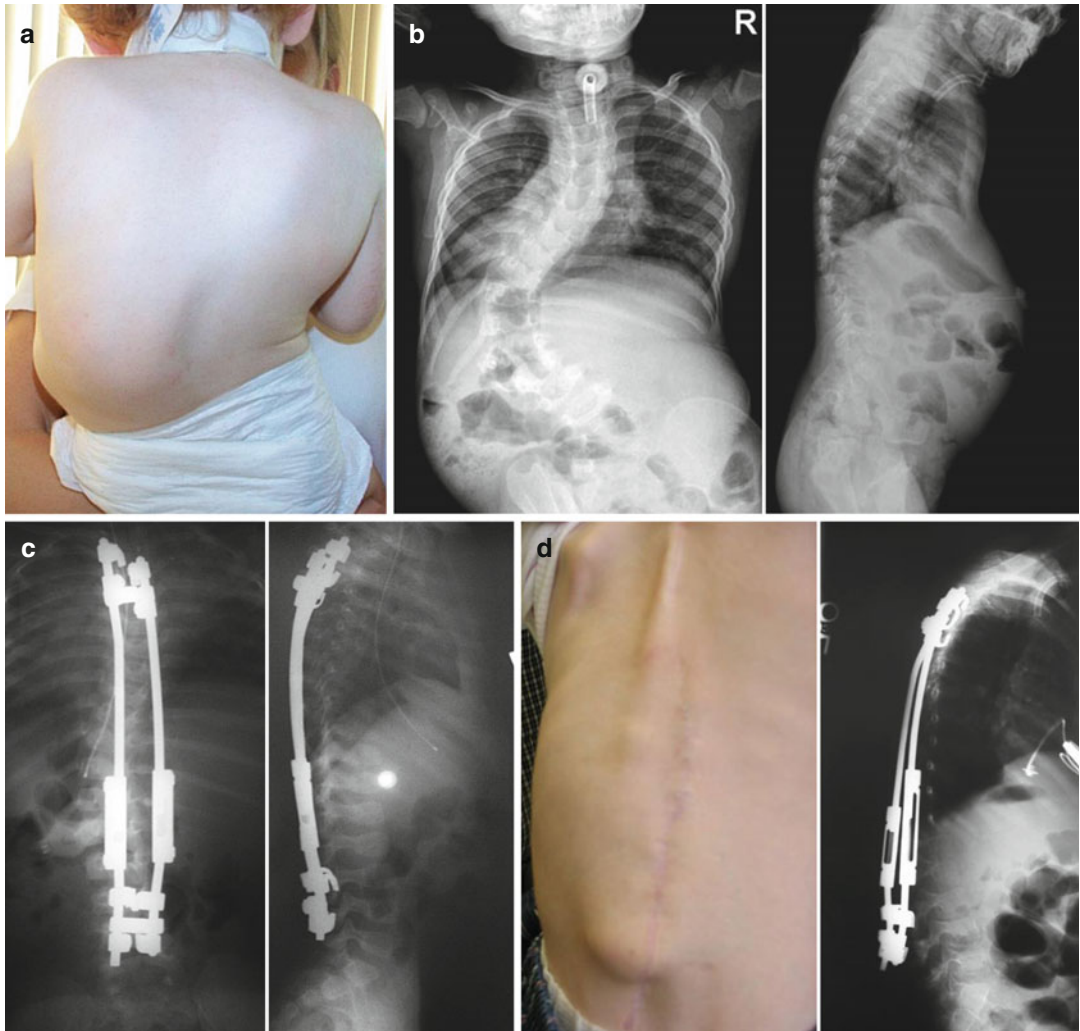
(a–g) A 30-month-old boy with idiopathic scoliosis (a). Anteroposterior and lateral pre-initial surgery radiographs (b). The patient underwent dual growing rod insertion from T3 to L4. Hooks were used at upper foundation (T3–T4) and lower foundation (L3–L4) (c). During 7 years active treatment, patient had multiple complications, treated through planned/unplanned surgeries. Hooks pull out at lower foundation; hooks were replaced
